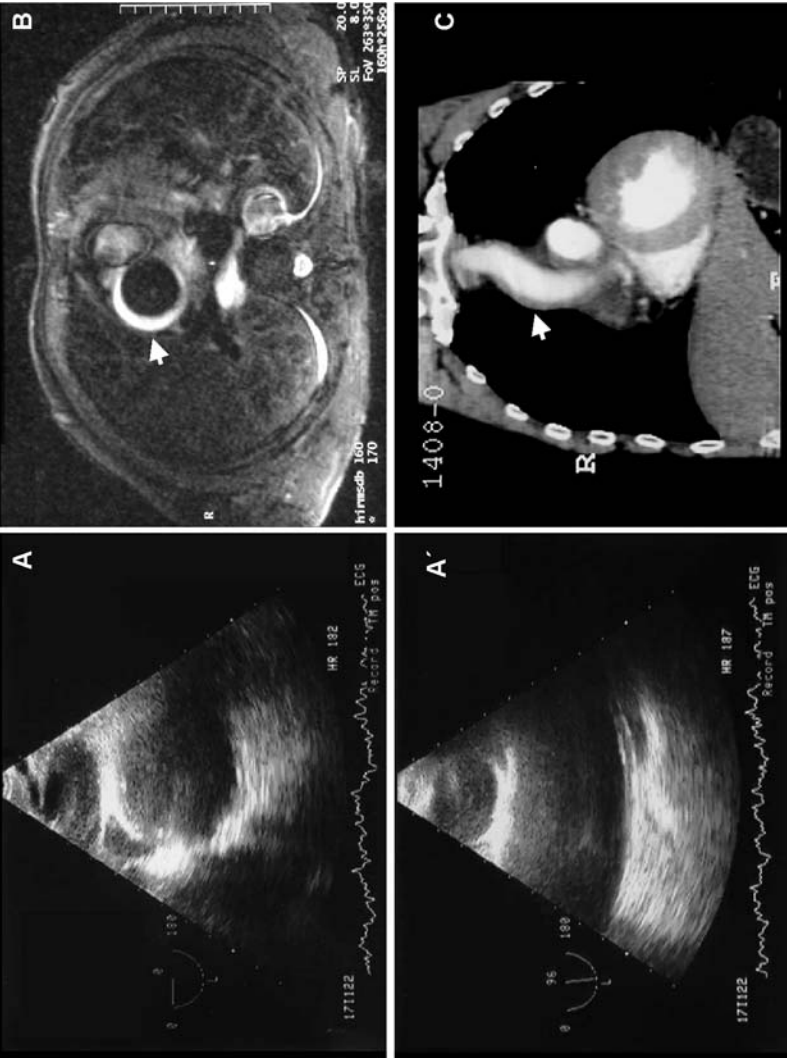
In left images, TEE in transverse (A) and longitudinal (A') views show minimal thickening of the ascending aorta wall, which was not diagnosed as abnormal. B. CMR performed 72 hours latter shows hyperintense signal in ascending aorta wall diagnosed as type A IMH. C. CT performed the same day as CMR discloses a small thickening of the aorta wall. The diagnosis of INH was only considered definitive in the CMR study.
